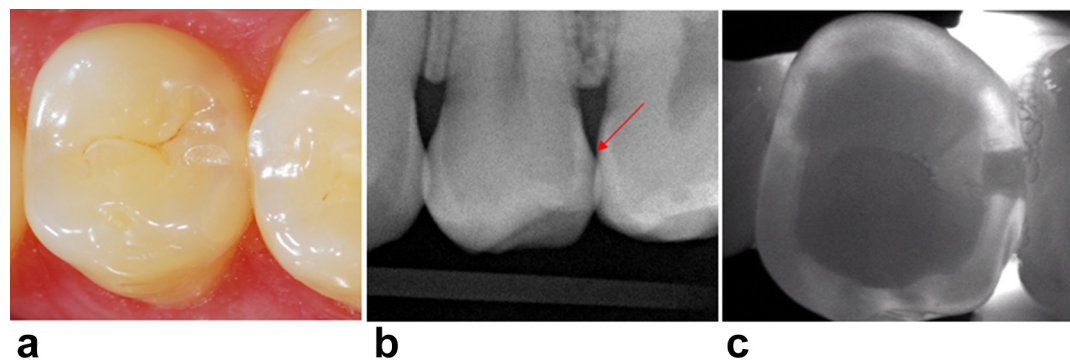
Clinical example of the distal surface of a premolar: (a) no visual signs of a proximal caries lesion; (b) digital bitewing radiograph: radiological translucence involved the enamel–dentin junction and reached the part of the dentin (D3 level); (c) near-infrared light image: a rectangular shading in the enamel with linear contact to the dentino–enamel junction (Score 4). Both, DBW and NIRT image, indicate a dentin caries lesion. DBW, digital bitewing; NIRT, near-infrared light transillumination.
